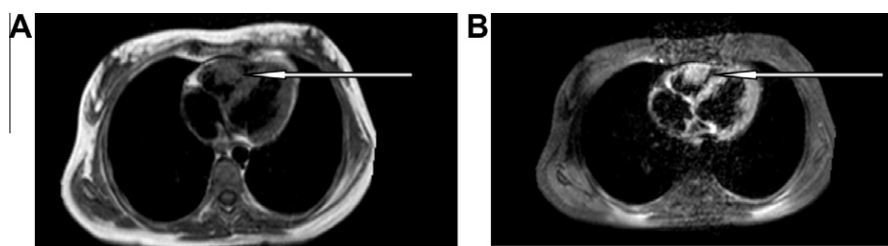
Cardiac MRI showing the RV mass. (A) Without contrast and (B) with contrast.
